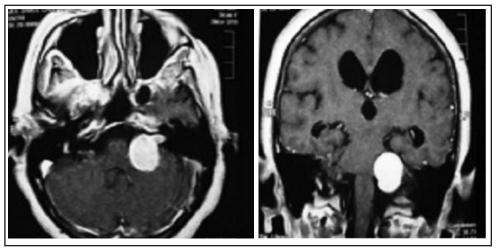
Preoperative MRI brain scan shows the left acoustic neuroma.
